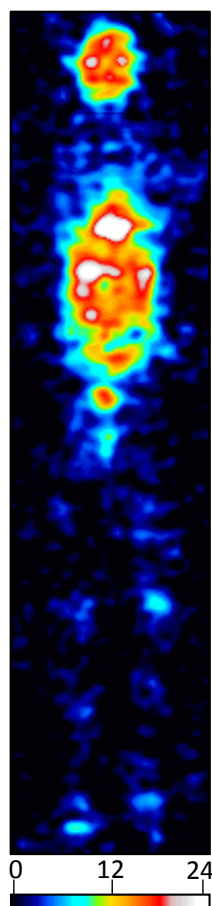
The sum of the WB  $^{23}\text{Na}$  MR images obtained in prone and supine positions.
